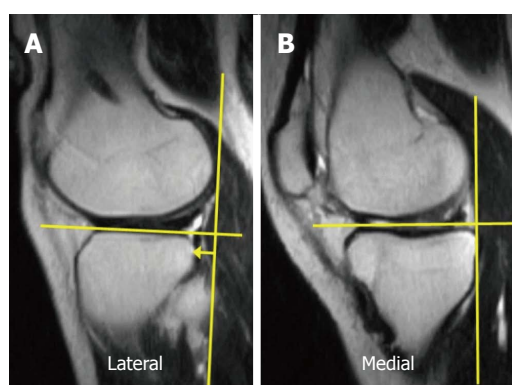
The anterior translation of the tibia with respect to the femoral condyle was measured on sagittal MR images of the (A) lateral compartment and (B) medial compartment, respectively. As a landmark for the center of the lateral compartment, slices that included the medial edge of the fibula were selected. For the center of the medial compartment, slices with the attachment of the medial head of the gastrocnemius were selected.
